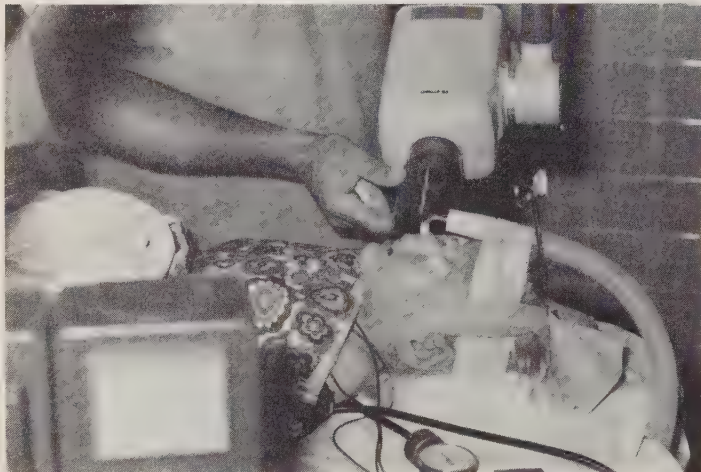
Oral roentgenographs being taken in the OR after the child has been anaesthetized.
